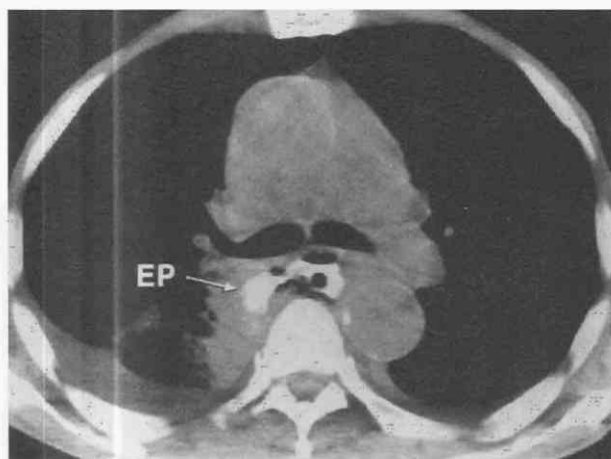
Acute mediastinitis after perforation of esophageal carcinoma. CT shows extravasation of esophageal contrast (EP) and air into mediastinum after perforation. A small right pleural effusion can be seen.
